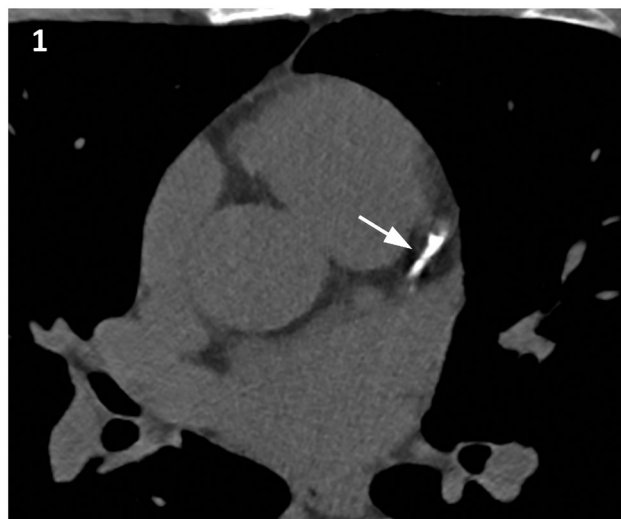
Non-contrast-enhanced cardiac computed tomography with axial oblique maximum intensity projection images showing single-vessel calcified coronary artery disease. Coronary artery calcium predominates at the level of the mid-segment of the left anterior descending artery (arrow).
